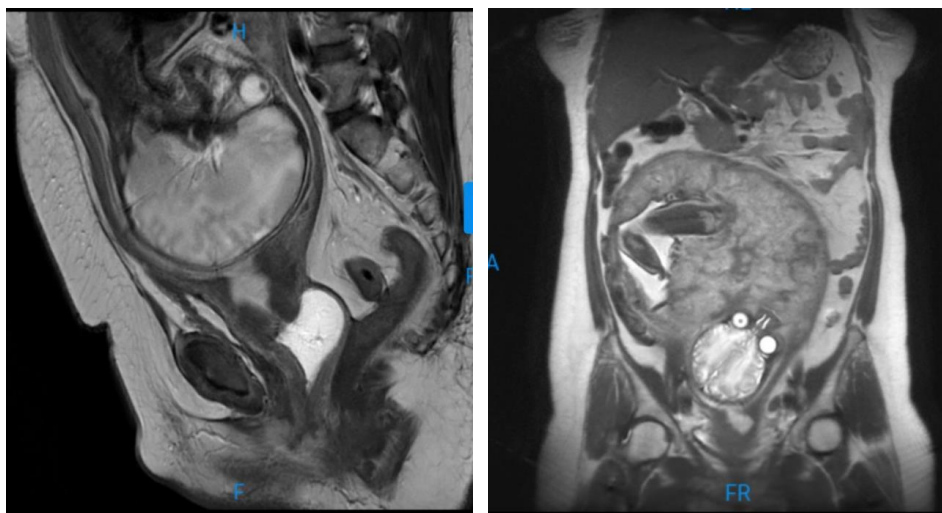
Pelvic MRI demonstrating Stage IIA2 cervical cancer.
